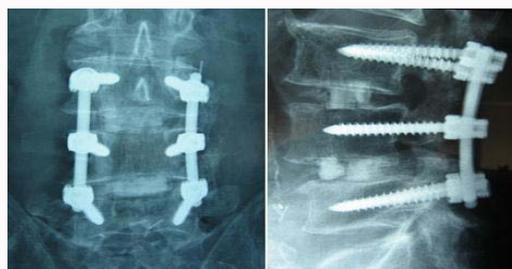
Post op check X-ray of the L/S spine following instrumented fusion with pedicle screws and cage.
